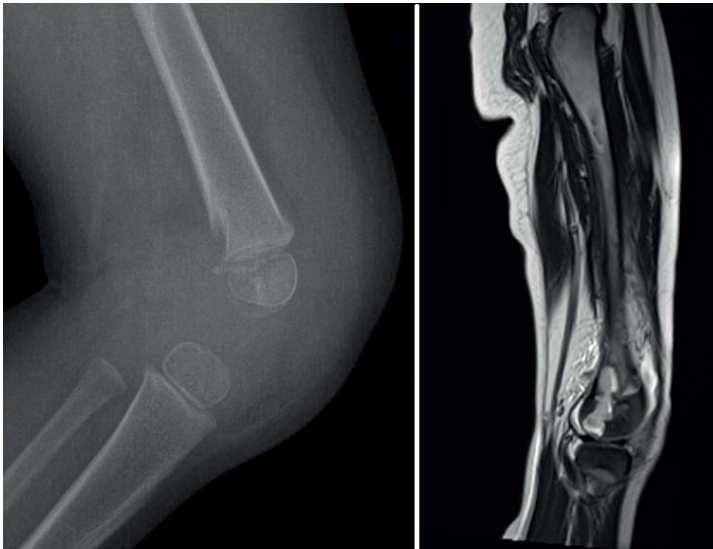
A 2 years and 4 months old boy presented one day fever, weight bearing refusal and reduced articular range of motion from 1 month. After 2 weeks appeared left knee swelling. At the X-rays lateral view we observe a posterior cortex irregularity, periosteal reaction and soft tissues swelling. On MRI, a low density lesion with peripheral contrast enhancement is recognizable on the posterior-lateral side of the distal femur crossing the growth cartilage and invading the physis. The microbial culture of the synovial fluid was negative. The first pharmacological treatment used Linezolid and Ceftriaxone without healing marks. After 6 days the antibiotics were interrupted and a treatment with Meropenem started which led the patient to healing.
